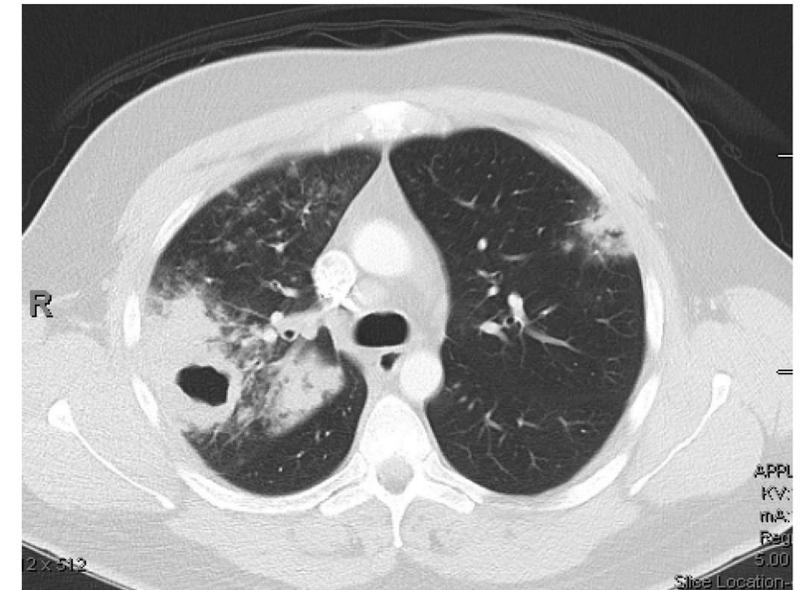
Initial CT scan with multifocal pneumonia and cavitory lesion
